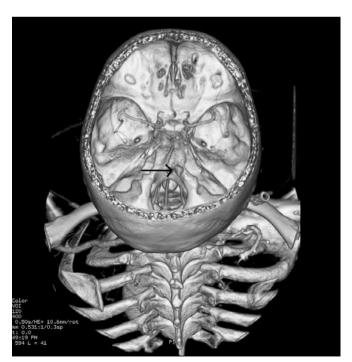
3D reconstruction of a head CT angiogram demonstrates a saccular aneurysm at the right distal vertebral artery at the origin of the right PICA. The aneurysm points posteriorly and slightly superiorly, and measures 7mm in length with a 6mm neck. The aneurysm is irregular in shape, consistent with recent bleeding.
